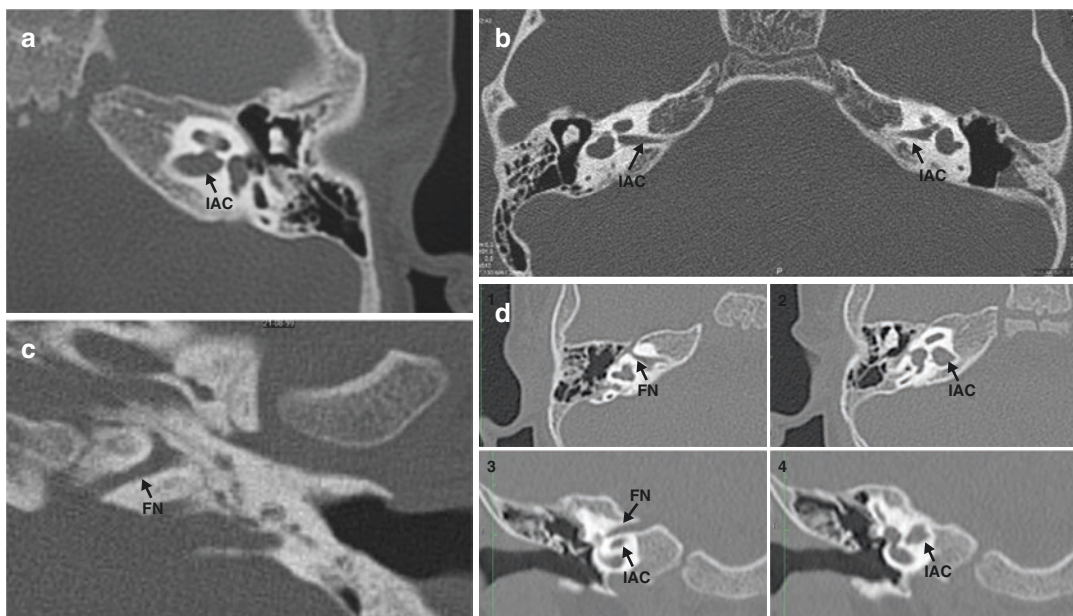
(a) Normal meatal segment (normal internal auditory canal): Internal auditory canal (IAC) is normal when its midpoint diameter is ≥ 2 mm S. (b) Narrow meatal segment (Narrow IAC): Bilateral narrow IAC where the midpoint diameter is < 2 mm (cochlear nerve may be hypoplastic or aplastic on MRI). (c) Only facial canal: IAC consists of facial canal (FN) only; FN has its
